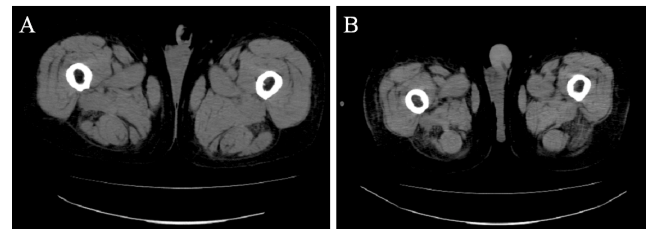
CT scans of the thigh in a patient with septic shock at baseline (A) and seven days later (B), showing the changes in muscle volume.
